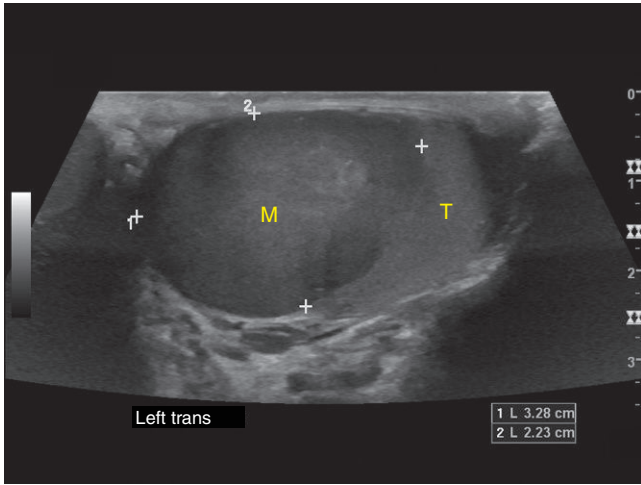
Longitudinal ultrasound through the testis (T) demonstrates a hypoechoic mass (M) noted by calipers.
